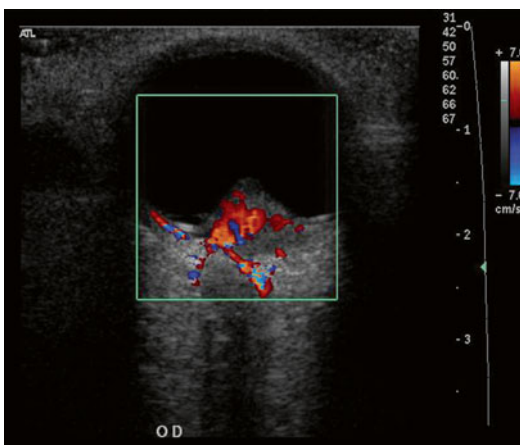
Color Doppler image of an intraocular tumor
